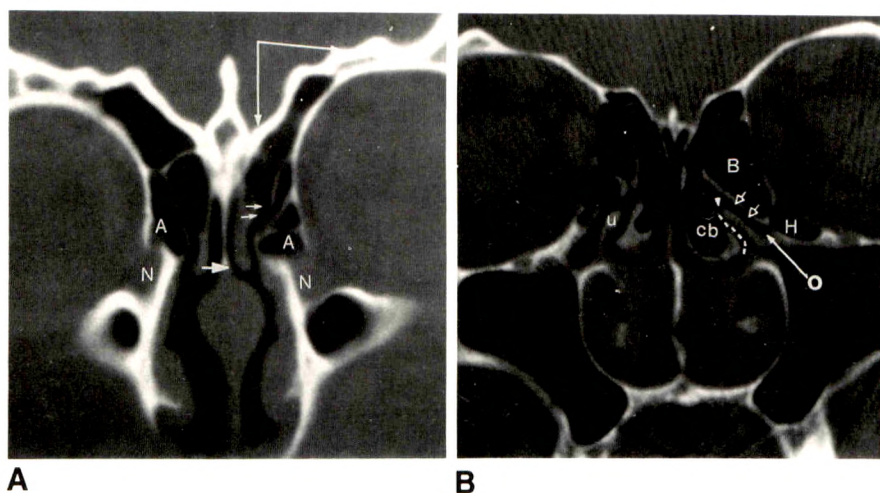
A, Coronal CT scan shows agger nasi cells (A), frontal recess (two small arrows), supraorbital anterior ethmoidal air cells, nasolacrimal canal (N), perpendicular plate of ethmoid bone (single short arrow), and fovea ethmoidalis (long arrows).
